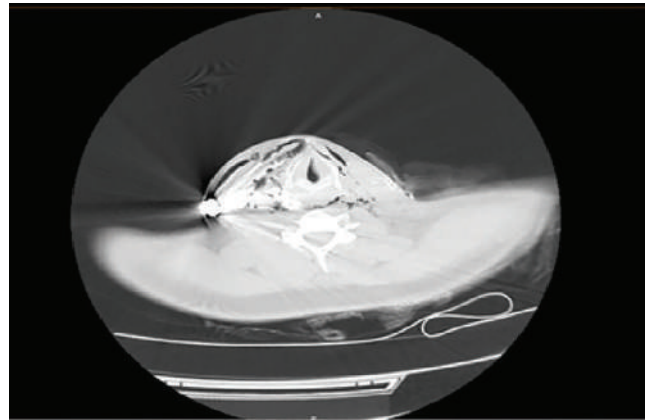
Contrast-enhanced cervical computed tomography demonstrating pneumomediastinum secondary to a cervical gunshot wound and a subcutaneously located bullet in the right cervical region.
